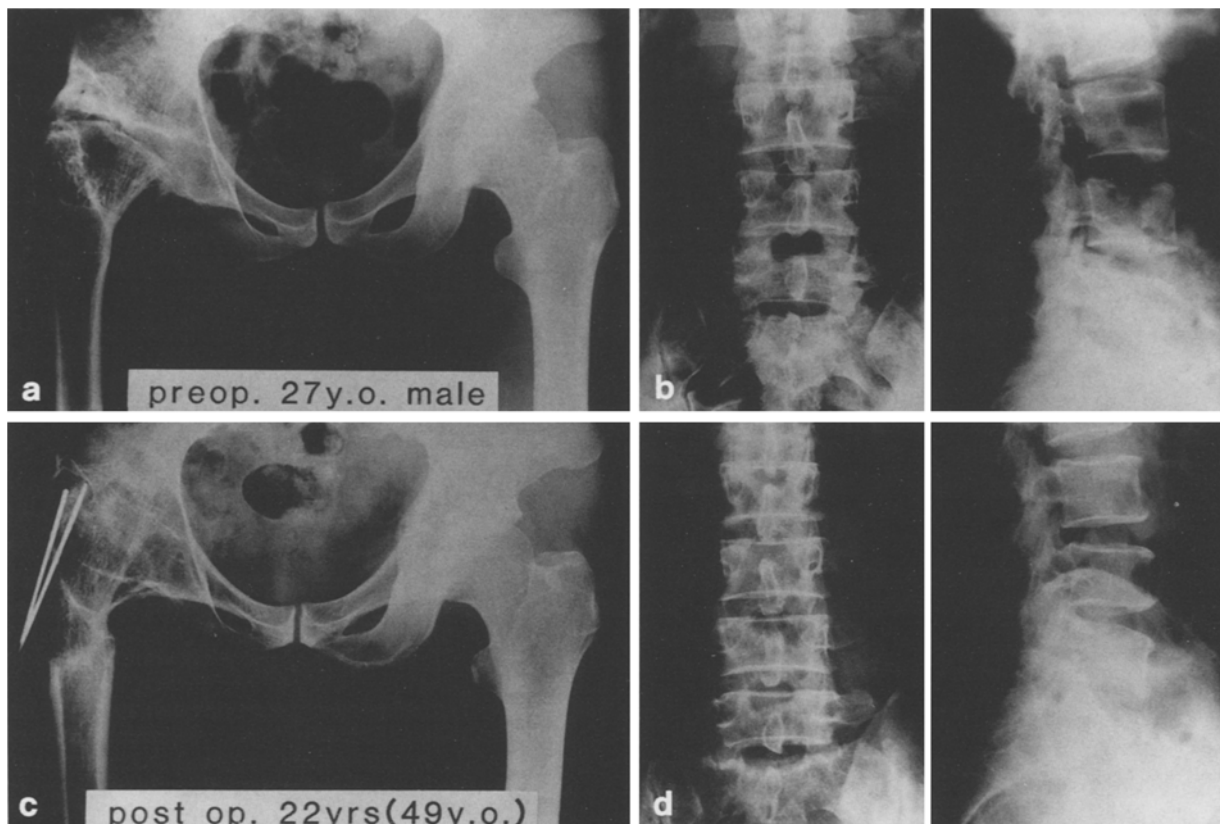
a–d. Radiographs of a 27 year old man before arthrodesis showing that the opposite hip and lumbar spine are normal (a, b). Radiographs 22 years after arthrodesis. The opposite hip and lumbar spine remain normal (c, d)
